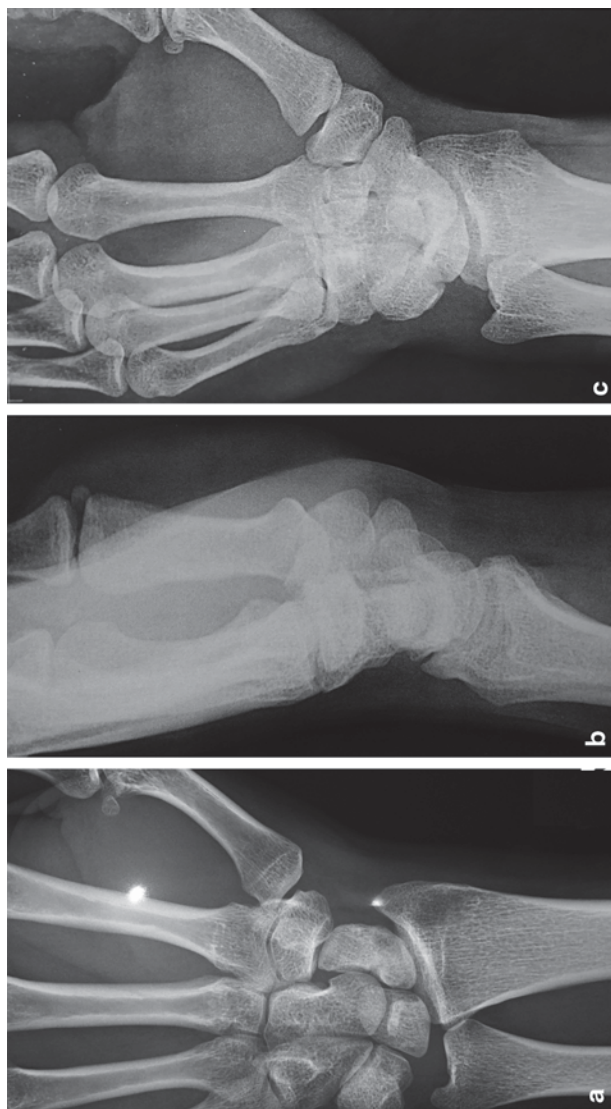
a, b, c X-rays and clinical view of wrist at 45 days after the removal of K-wires. (Published with kind permission of ©Christophe Mathoulin 2015. All Rights Reserved)
